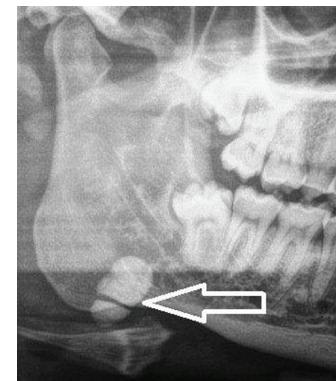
Panoramic radiograph (cropped) presenting a large sialolith (arrow) in the duct of the right submandibular gland.
